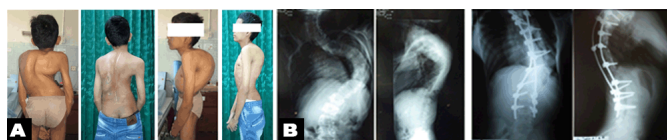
(A and B): First patient case presentation: clinical picture (A) and X-ray (B) pre- and post-operative.
